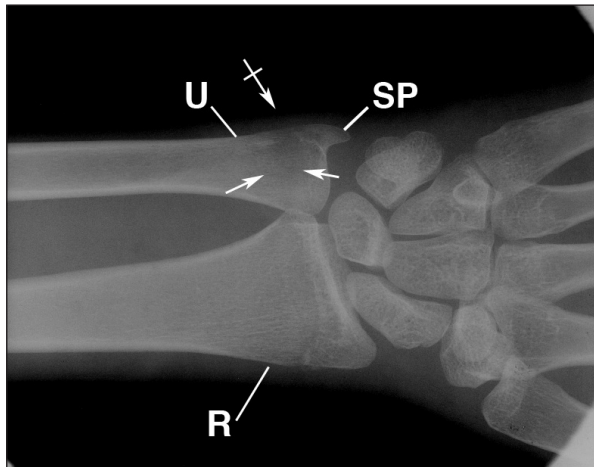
This anteroposterior wrist radiograph displays advanced lytic destruction of the distal ulna (arrows), the styloid process, and further cortical breakdown with increased soft tissue swelling (bar arrow).
